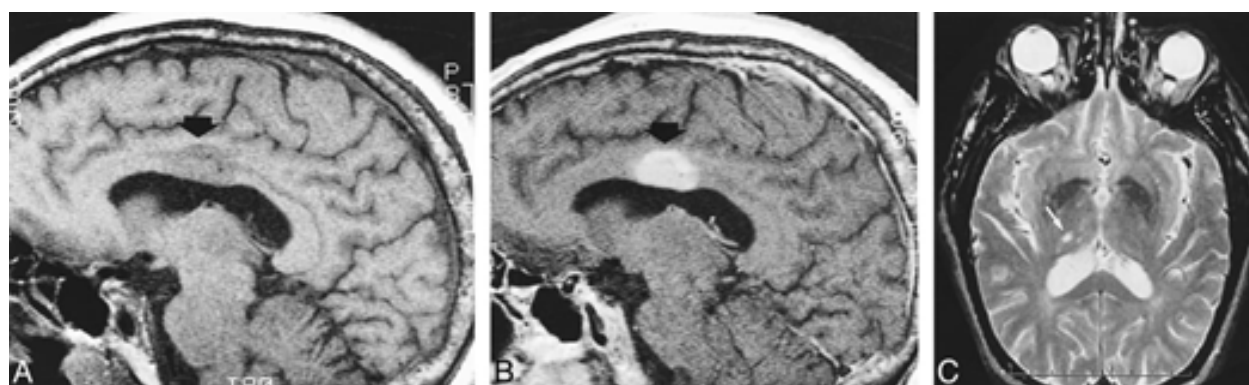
MRI Scan of Acute Infarct in Corpus Collasum
